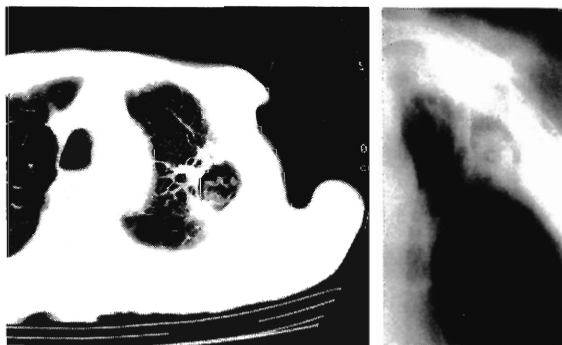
"Spongiform" fungus ball observed by CT scan (left) and tomography (right).
